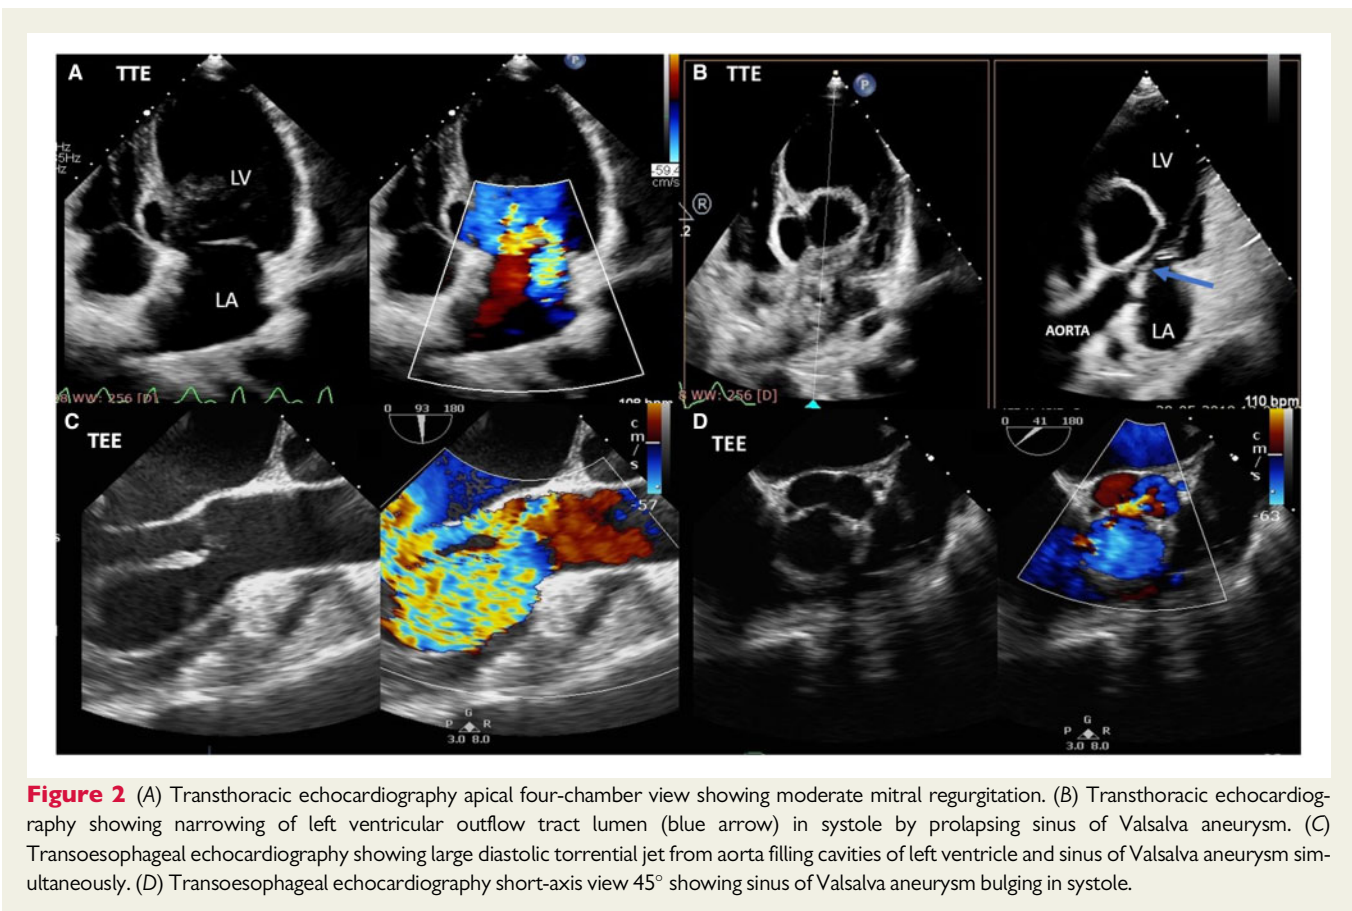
(A) Transthoracic echocardiography apical four-chamber view showing moderate mitral regurgitation. (B) Transthoracic echocardiography showing narrowing of left ventricular outflow tract lumen (blue arrow) in systole by prolapsing sinus of Valsalva aneurysm. (C) Transoesophageal echocardiography showing large diastolic torrential jet from aorta filling cavities of left ventricle and sinus of Valsalva aneurysm simultaneously. (D) Transoesophageal echocardiography short-axis view 45° showing sinus of Valsalva aneurysm bulging in systole.
